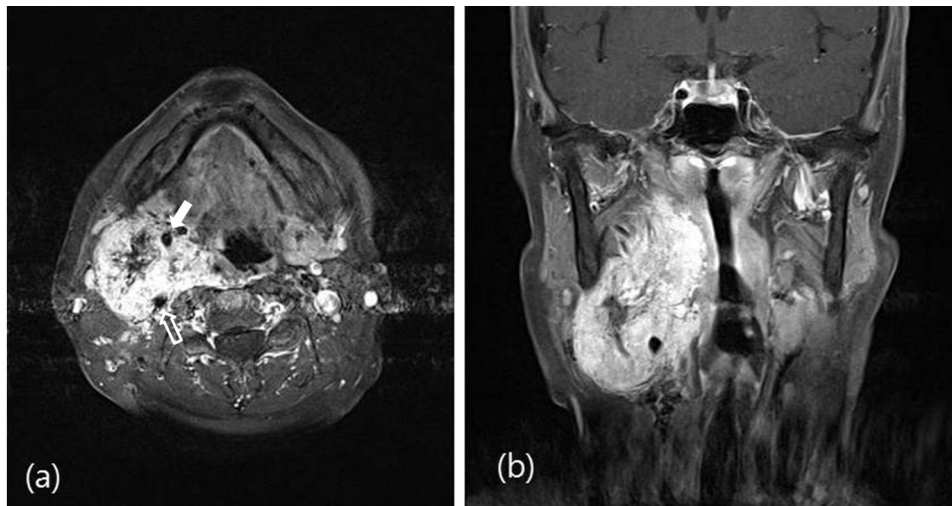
Preoperative MR images. (a) Coronal image of carotid body tumor. Mass is placed between external (white arrow) and internal carotid artery (empty arrow). (b) Sagittal section of main mass. The mass extends from carotid body to skull base causing compressive effect to adjacent structures.
